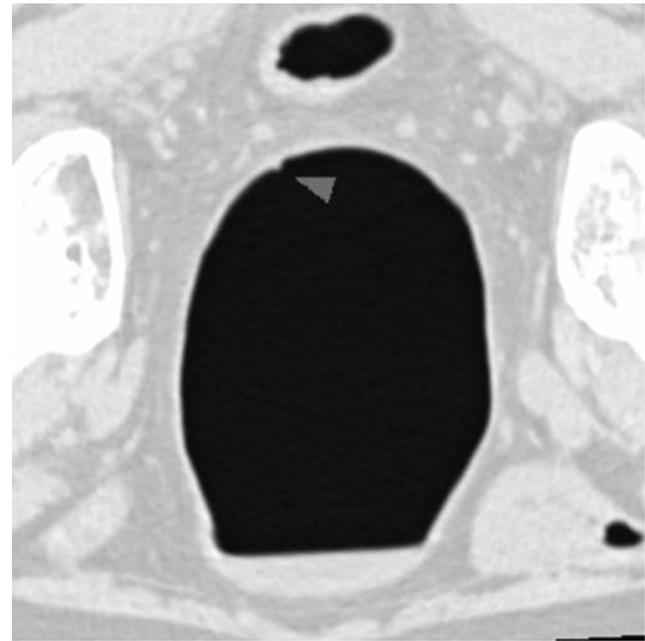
(A) False-negative transabdominal ultrasonography. (B) Axial image of bladder walls showing a small irregularity (arrow). (C) Three-dimensional air-content image of the bladder revealing a small tumor (which corresponds to the bladder wall irregularity in B).
